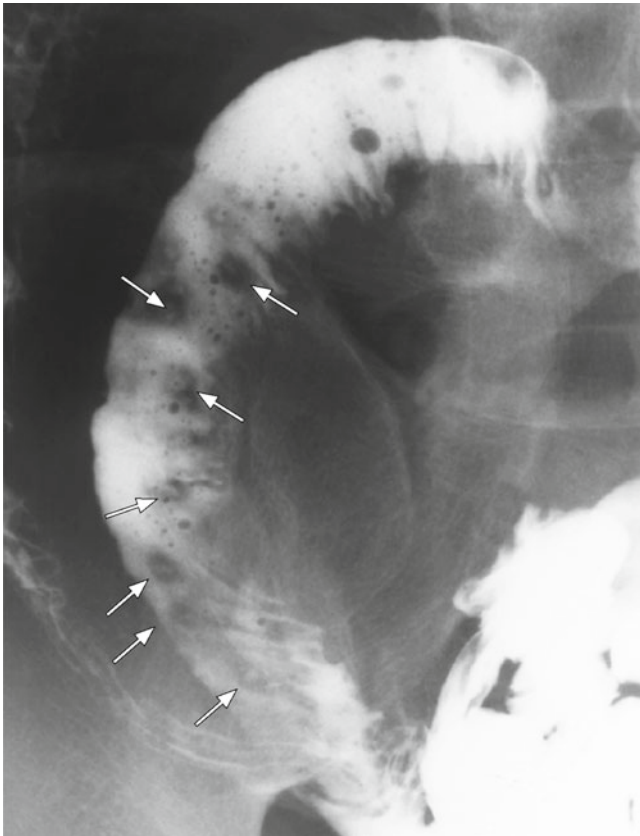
In this radiographic image, small barium flecks and surrounding filling defects were visualized in the middle to lower small intestine (*arrows*)
